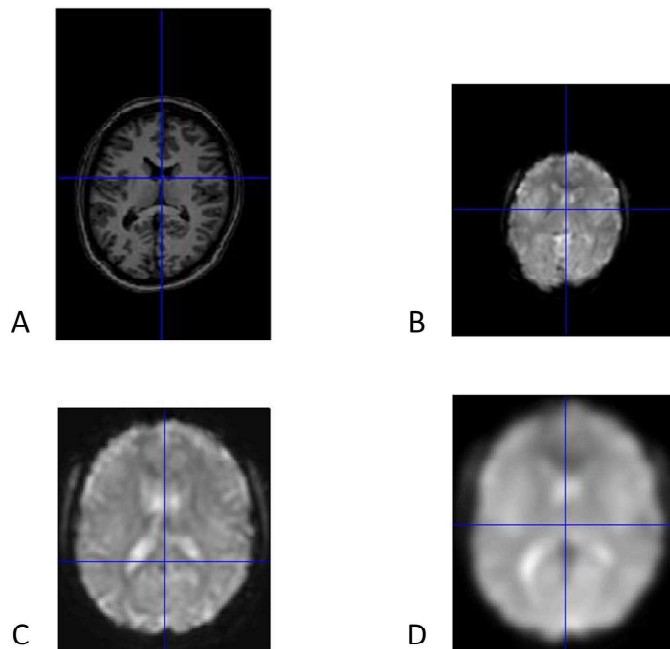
(A) Structural (T1-weighted) image, (B) Functional motion-corrected T2*-weighted image, (C) Functional image normalised to the MNI template, and (D) Normalised functional image after smoothing of the same coronal slice of one representative subject.
